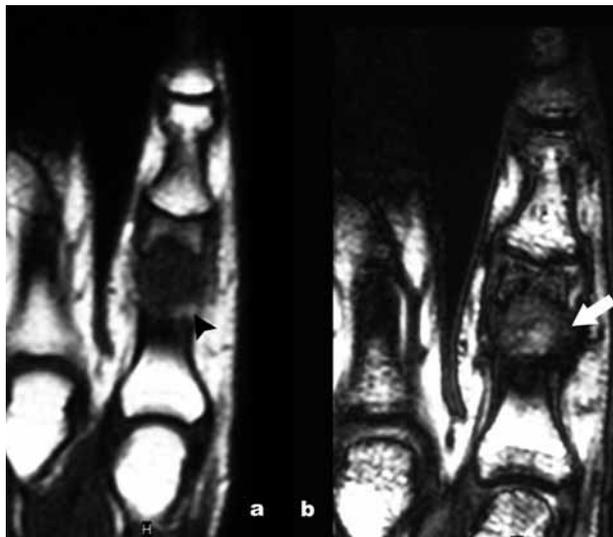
a) Coronal T1 weighted MR image (TR = 260, TE = 17). The tumour has indistinct margination with intermediate intensity and a small area of increased uptake suggestive of intra-tumoral fat overgrowth (*arrowhead*); b) Coronal T2 Gradient Echo view of little finger (TR = 19, TE = 12, Flip = 50). The tumour is seen as a high signal intensity lesion (*arrow*) in relation to the distal end of the proximal phalanx.
